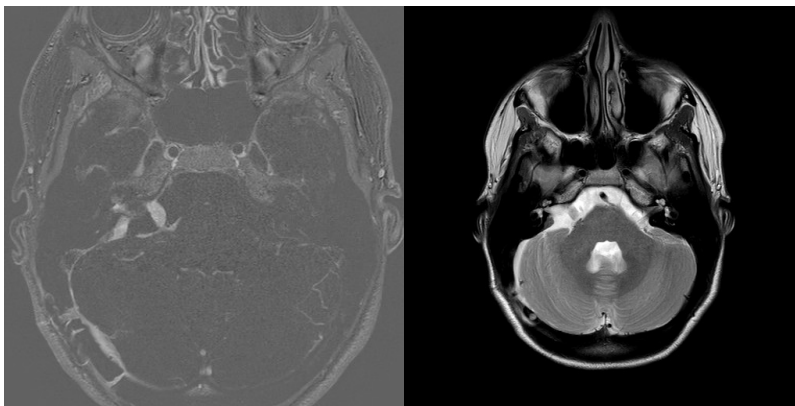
Last postoperative MRI with cochlear obliteration on the right side
